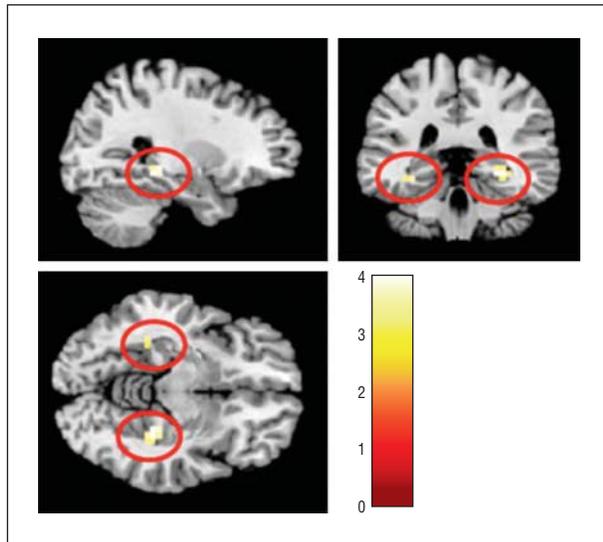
Decreased blood oxygenation level–dependent activation in young $\epsilon 4$ carriers compared with $\epsilon 3$ homozygotes. On 3 orthogonal magnetic resonance imaging templates, displayed in yellow are the areas where $\epsilon 4$ carriers aged 40 years or younger ($n=91$) demonstrated less activation ($P<.05$, familywise error corrected) of the hippocampi (right, x, y , and $z=26, -34$, and -8 ; left, $-30, -34$, and -11) during memory encoding compared with young $\epsilon 3$ homozygotes.
